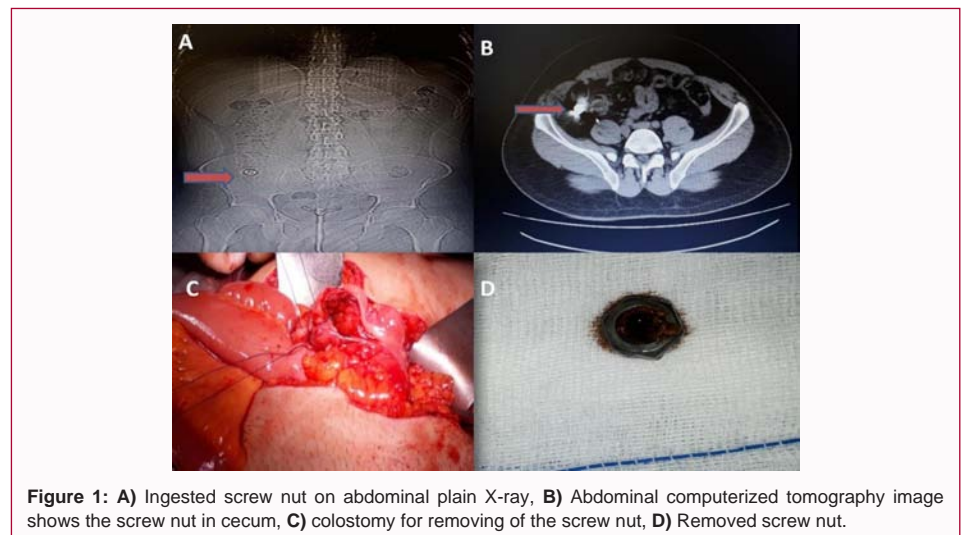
A) Ingested screw nut on abdominal plain X-ray, B) Abdominal computerized tomography image shows the screw nut in cecum, C) colostomy for removing of the screw nut, D) Removed screw nut.
